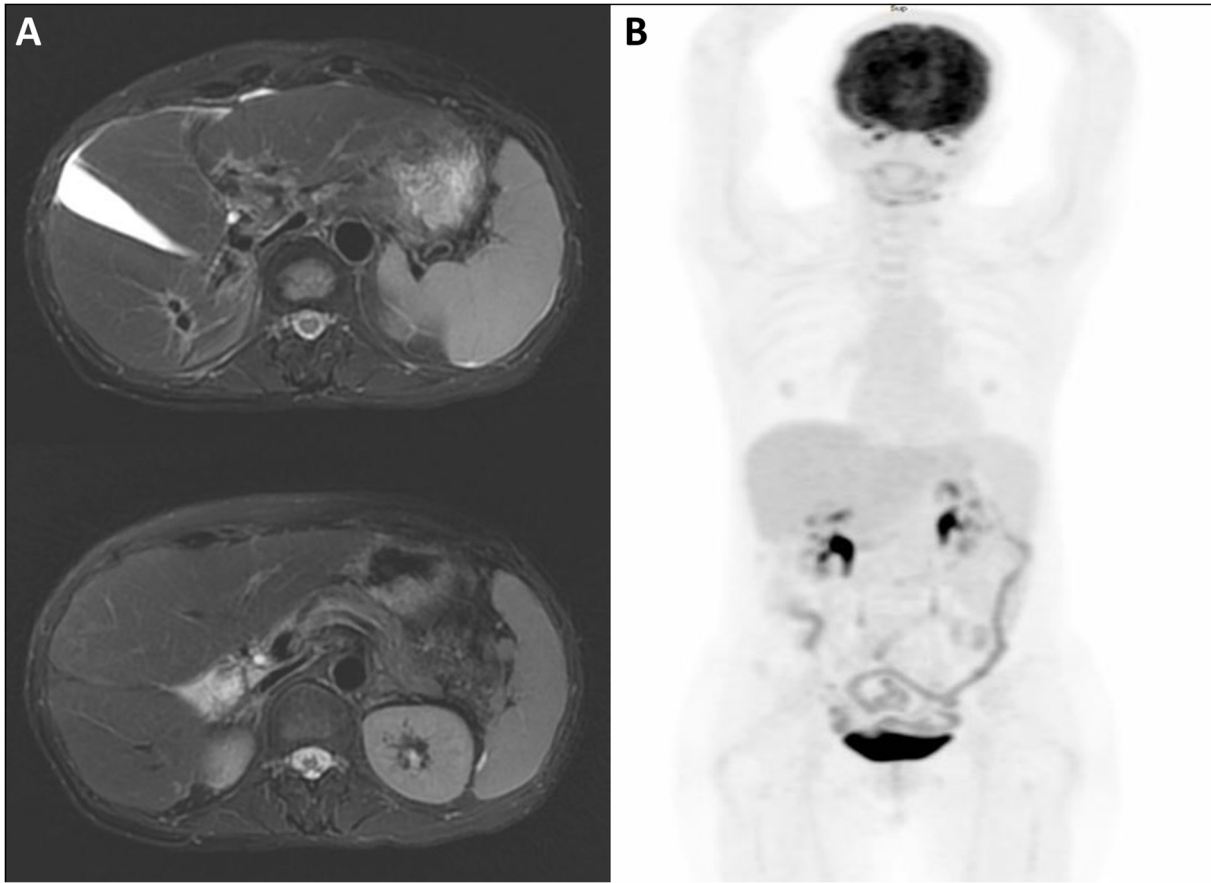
Post- involved site radiotherapy images. (A) Magnetic resonance imaging at 4 months and (B) positron emission tomography scan at 7 months demonstrating no evidence of malignancy.
